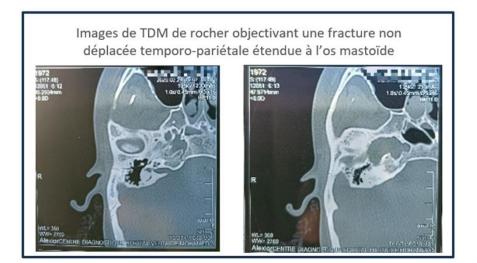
CT images of the petrous bone showing the non-displaced temporo-parietal fracture extending to the mastoid bone
